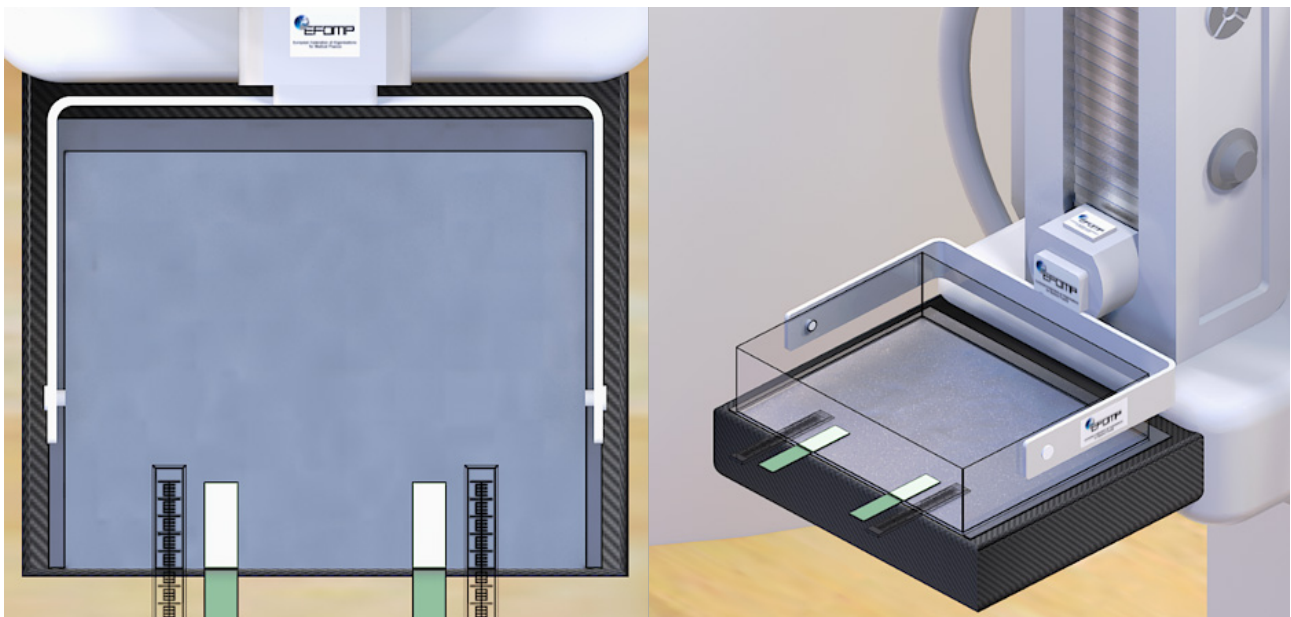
Setup for the x-ray beam alignment and collimation test
